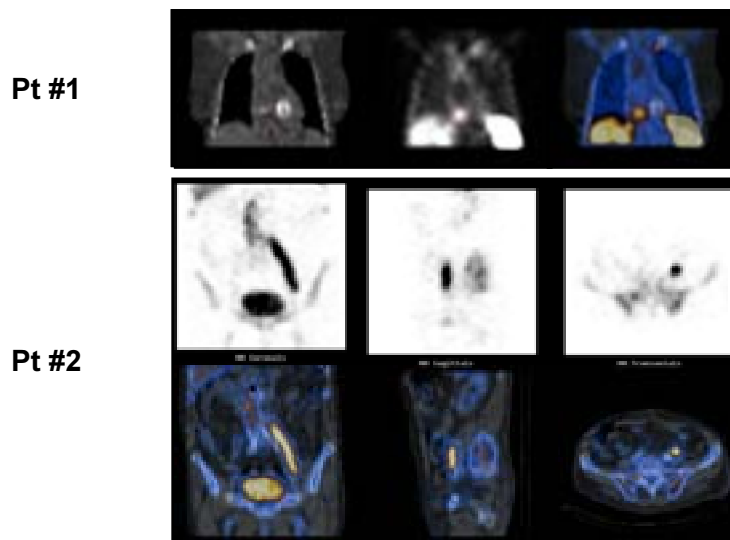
Patients with cardiovascular infection imaged with autologous ^{99m}Tc -HMPAO-leukocytes and SPECT/CT. Although the most likely site of endocardial infection in Pt # 1 was expected to be a mitral valve implant (visible on the CT component of the examination), SPECT/CT correctly identified the tricuspid valve as the actual site of infection (top panel). In Pt #2 (previously submitted to implant of aorto-bis-iliac vascular prosthesis), SPECT/CT defined the extent of infection as involving only the left side of the vascular graft (bottom panel).
